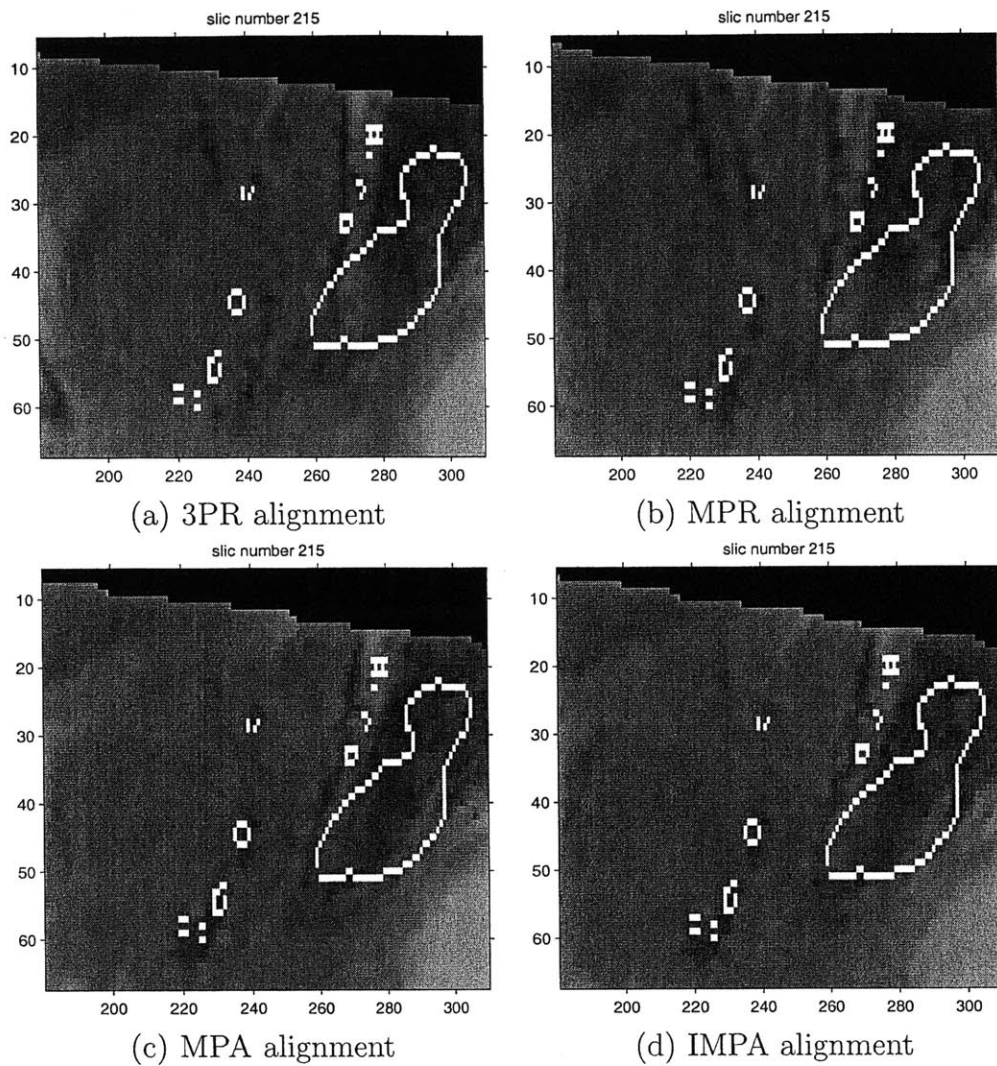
These slices are sagittal views of the same alignments shown axially in Figure 7.5. Again, edges found in the CT image are overlaid on reformatted MR slices. The 3PR alignment (a) shows a consistent error (larger than a seed length) in aligning dark MR seeds with overlaid white CT seeds. MPR (b) shows improvements over 3PR. MPA (c) and IMPA (c) show improvements over both 3PR and MPR, especially in the upper right hand corner. MPA and IMPA are very similar, as expected.
